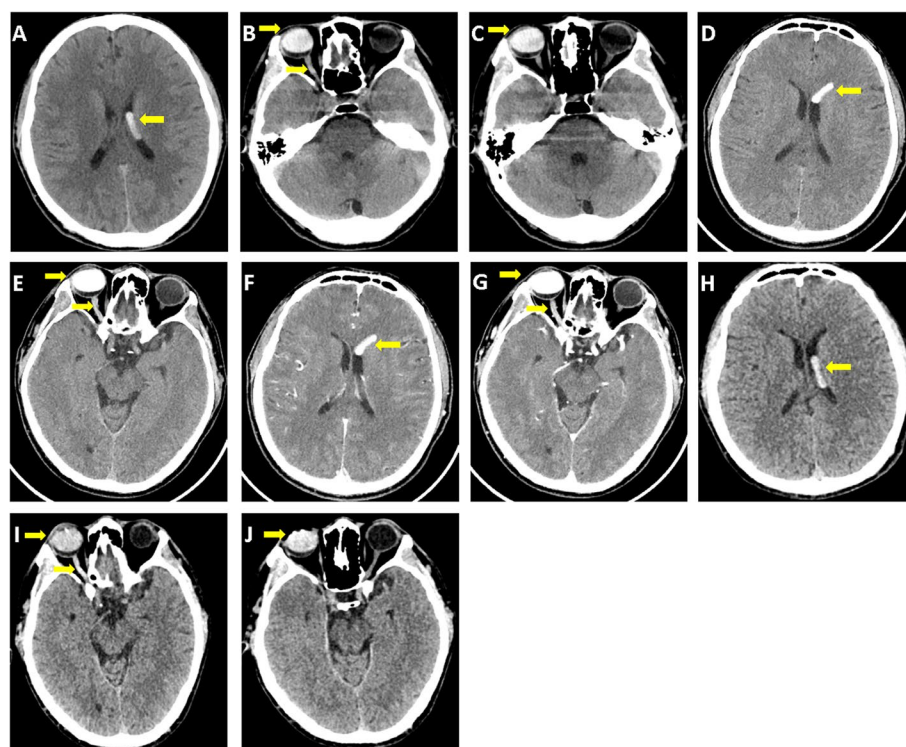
Nonenhanced brain CT demonstrated nondependent hyperdensities in the the left ventricle (A, yellow arrow), as well as in the right eye globes and in the right optic nerve (B–C, yellow arrow). The right optic nerve had a larger density than the left, which was close to intraocular silicone oil (B–C). First Enhanced brain CT revealed that nondependent hyperdensities in the the left ventricle (D), as well as in the right eye globes and in the right optic nerve (E), and demonstrated no enhancement of these silicone particles (F–G). Head CT reexamination of the patient 4 months after the discovery of the ventricle high-density lesion showed that the size of the high-density lesion in the lateral ventricle was similar to that before, the density was lower than before, and the position was more forward and backward (H–J)
